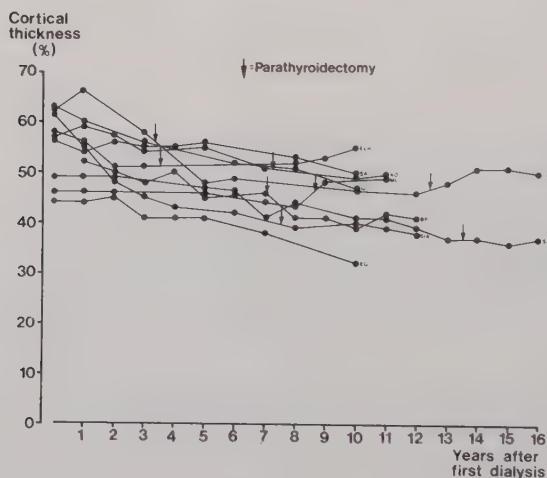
The change of cortical thickness on X-ray in 10 patients dialyzed for 10 years or more. ↓ denotes parathyroidectomy.
